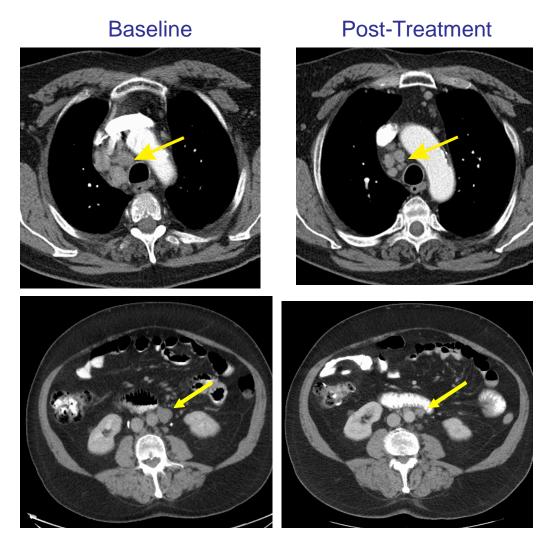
Objective Tumor Responses.Shown are baseline and post-treatment (3- or 6-month) CT
